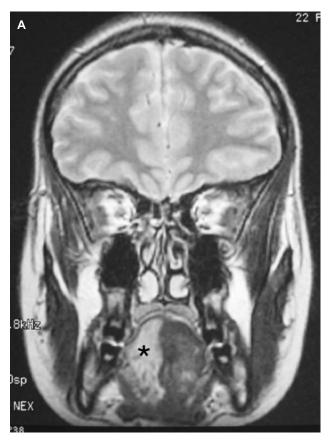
(A) Coronal T1-weighted head MR image demonstrating right tongue atrophy (asterisk) secondary to XII cranial nerve schwannoma - this girl's first NF2 manifestations were two lumps in the right hand misdiagnosed as plexiform neurofibromas the diagnosis being postponed until tongue atrophy and brain MR scanning showed multiple cranial schwannomas and meningiomas; (B) coronal T1-weighted spinal MR image of the same child in (Fig. 3B) showing a large paravertebral plexiform schwannoma extending from C1 to T1 which distorts the spine and protrudes in the left thoracic wall (white arrows); (C) coronal CT scan images showing two large pelvic masses (white arrows) occupying the entire pelvic region. These masses, which were palpable at physical examination and dislocated the urinary bladder, led the general pediatrician to refer the child to a pediatric oncologist and in turn to the suspicion of "a form of NF" because of café-au-lait spots - the diagnosis of NF2 was then clinically raised because of the presence of typical NF2-plagues and confirmed at MRI because of a bilateral vestibular schwannomas and spinal meningiomas and schwannomas [reprinted with permission from Ruggieri et al. 2005].
